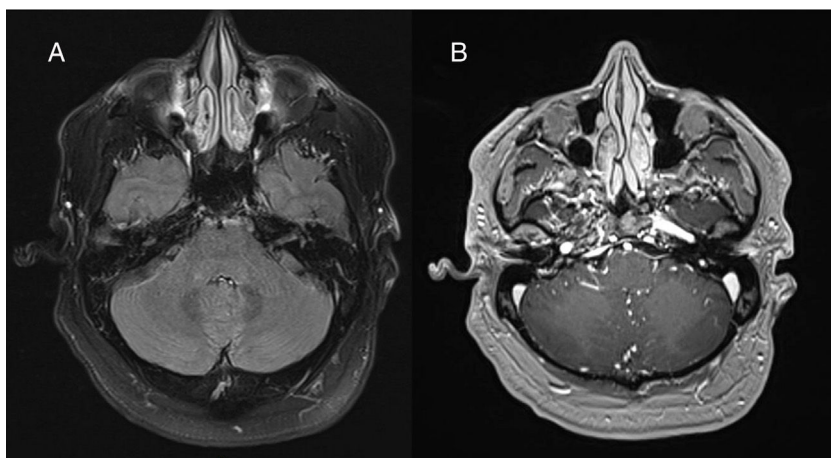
Axial T2-weighted FLAIR brain MRI scan obtained in a 3T scanner a month after onset of corticosteroid treatment with decreasing doses of prednisone, starting at 1 mg/kg/day. A) Complete disappearance of hyperintense lesions. B) No pathological lesions were observed after intravenous contrast administration.
